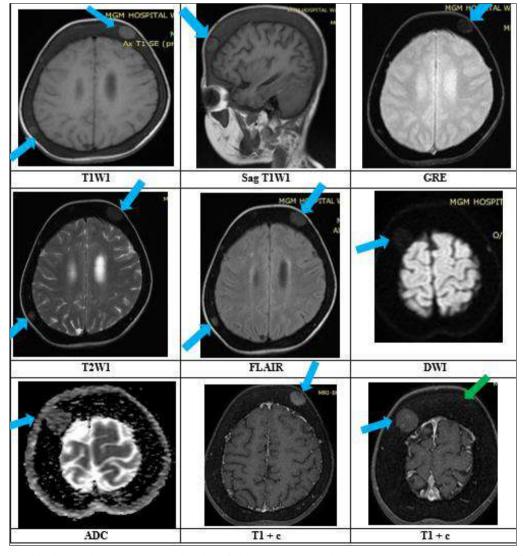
MR images of brain showing green arrow: widening of diploic spaces and blue arrow: homogenously enhancing soft tissue masses (EMH) within skull vault.
